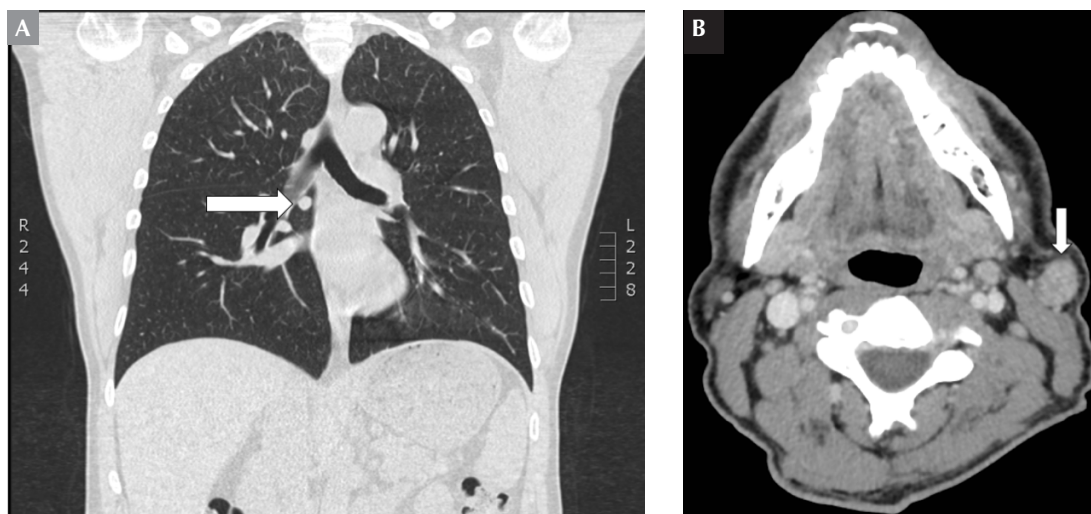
Computed tomography evidence of recurrent disease. (A) Coronal image demonstrating a new right pulmonary nodule measuring 9 mm (arrow). (B) Axial image demonstrating a 1.4 cm lesion inferior to the left parotid gland (arrow).
